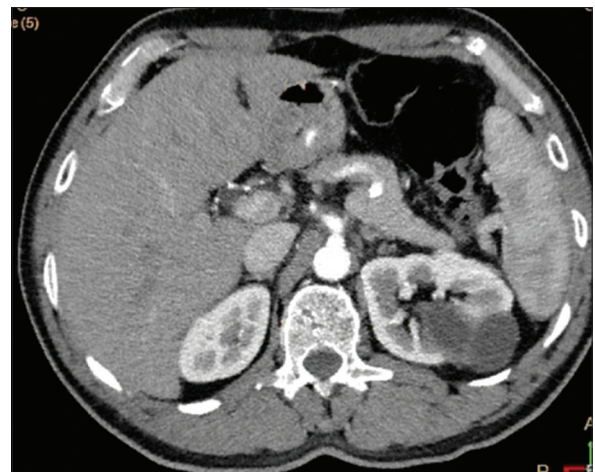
Left renal hydatid cyst (computed tomography scan with contrast, axial cut)
